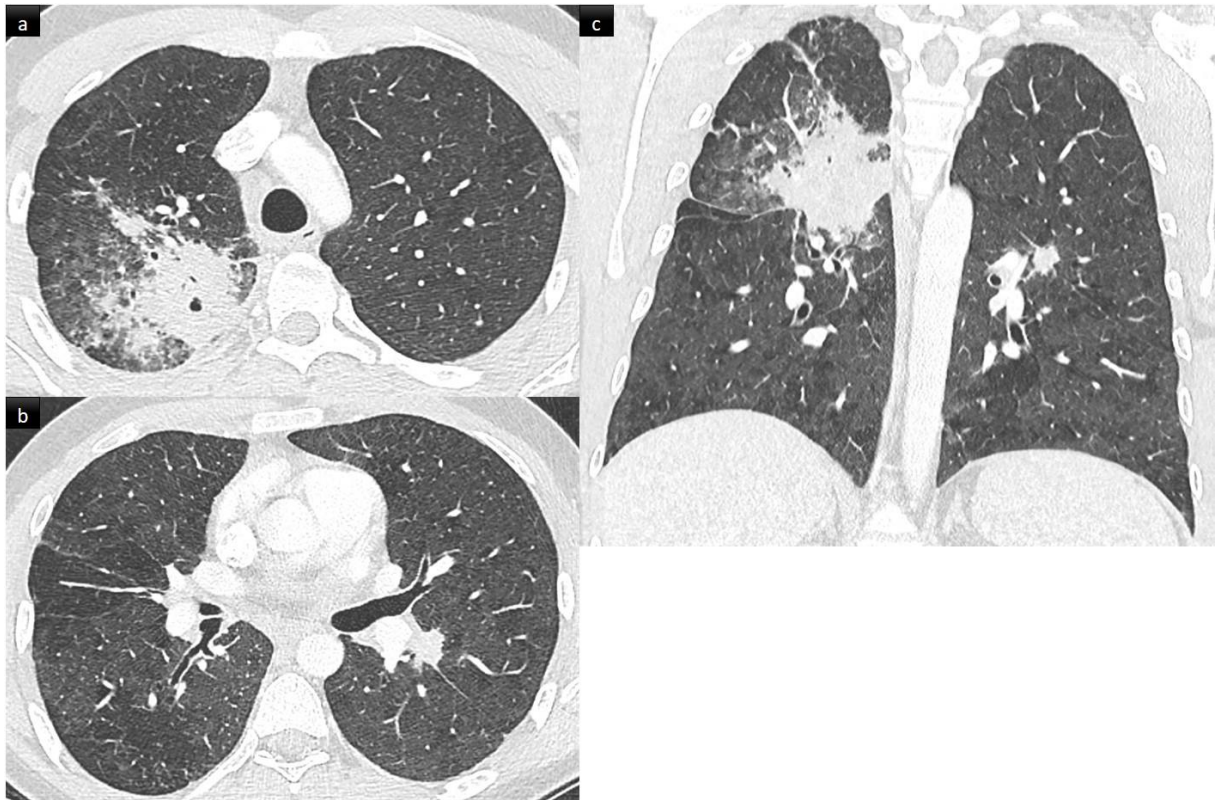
Invasive aspergillosis revealing chronic granulomatous disease in a young patient referred for fever and hemoptysis. Axial (a, b) and coronal (c) CT images in lung window show a large necrotizing mass in the right upper lobe, with transfissural extension towards the right lower lobe. There is a second nodule adjacent to the fissure on the left that reduced with antifungal treatment. Note the presence of mosaicism in other parts of the lungs (arrows), consistent with obliterative bronchiolitis and suggesting previous episodes of pulmonary infections.
